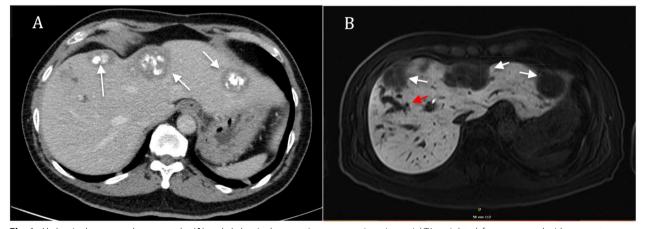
Abdominal computed tomography (A) and abdominal magnetic resonance imaging, axial T1-weighted, fat-suppressed with contrast in hepatobiliary-phase (B) of a 62-year-old patient with abdominal discomfort and elevated tumor markers. A shows multiple hypodense lesions with central calcification in both lobes (indicated by white arrows). No contrast enhancement raising concern for metastatic liver lesions or primary hepatocellular carcinoma. B shows multiple hypointense lesions up to 4.2 cm×3.8 cm, further raising concern for malignant pathology (indicated by white arrows). Diffuse wedge-shaped hypervascularisation during arterial phase in liver segments VIII and V with dilated intrahepatic bile ducts (indicated by red arrow)
